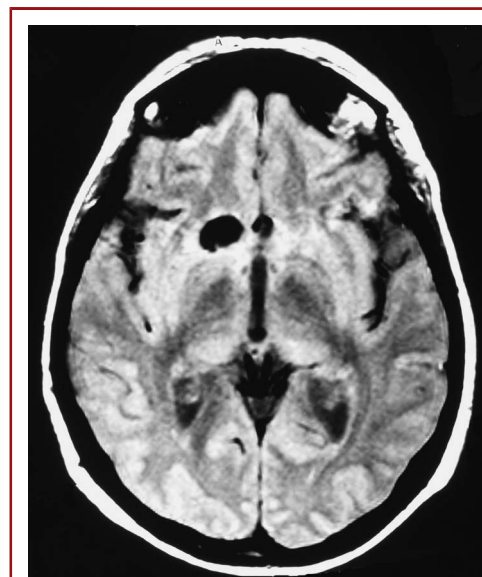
Magnetic resonance image showing a right-sided unruptured internal carotid artery bifurcation aneurysm measuring 15 mm.
